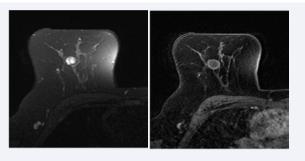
a,b: T2-weighted image on magnetic resonance imaging shows a well-circumscribed, hyperintense lesion. 3b. Contrastenhanced magnetic resonance imaging shows a thin rim enhanced cystic mass with internal septae.
